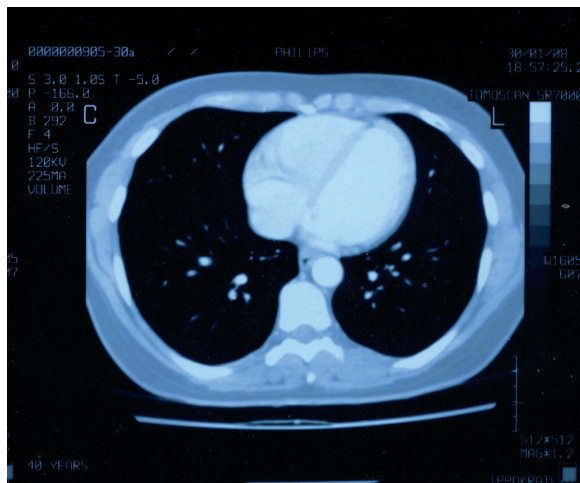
CT scan image of thorax showing minor findings suggesting interstitial pneumonitis.
